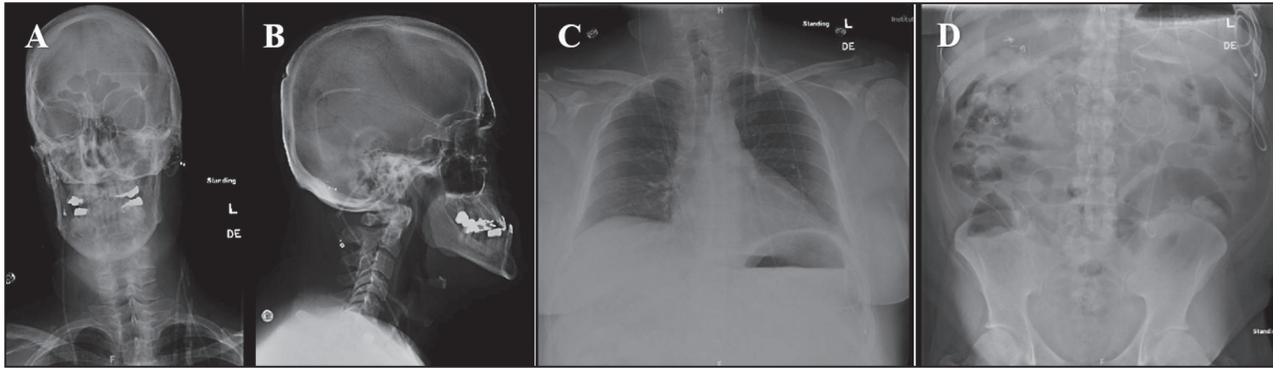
(A–D) Postoperative X-ray shunt series displaying the course of ventriculoperitoneal shunt from the head to peritoneal cavity following hernia repair and peritoneal catheter re-positioning
